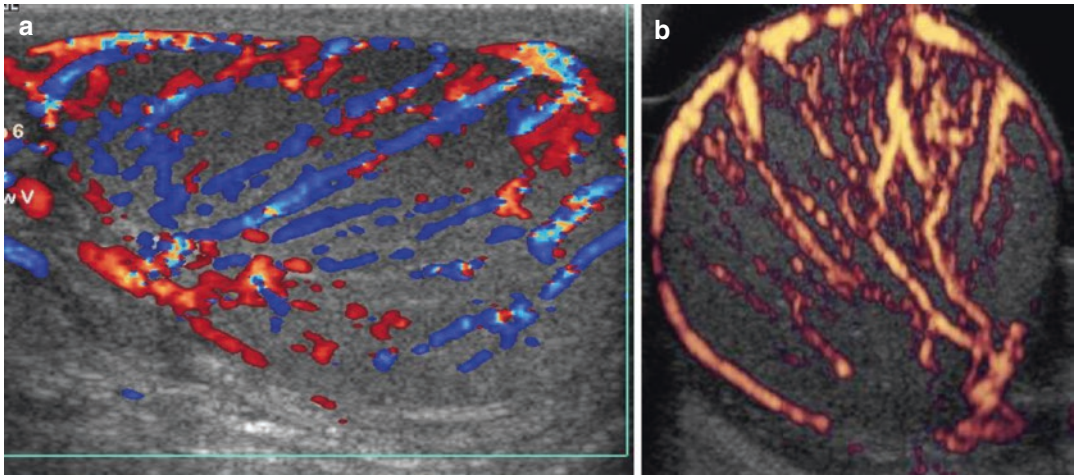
Color Doppler (a) and power Doppler (b) allow the assessment of the vascularity of the testis
